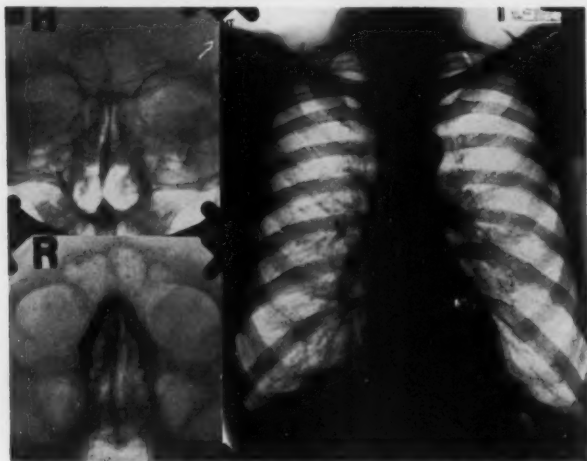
This patient has had bronchial asthma for a number of years. The Roentgen studies show chronic infection of the ethmoid and maxillary sinuses with chronic tracheobronchitis and emphysema of the lungs.
